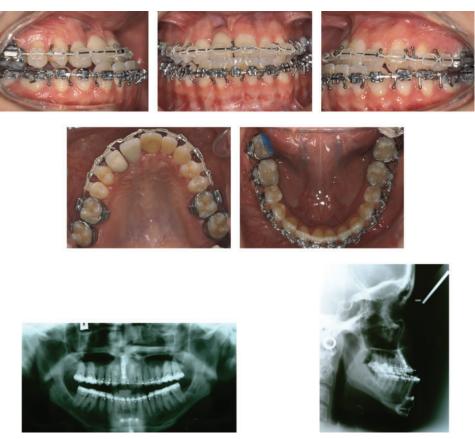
Pre-surgery intra-oral photographs and radiographs
